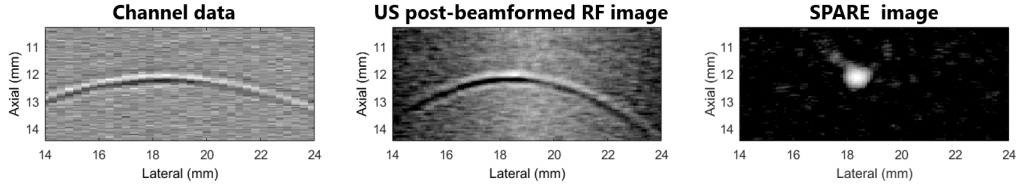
Experimental SPARE beamforming results with dynamic focusing. Original channel data, intermediate ultrasound post-beamformed result, and final SPARE post-beamformed result are shown from left to right, respectively. The dynamic range of 20 dB was used for display.
